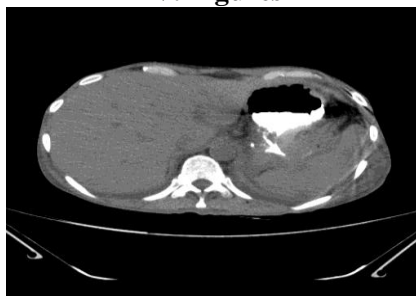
CT showing pseudocyst at the tail of pancreas
